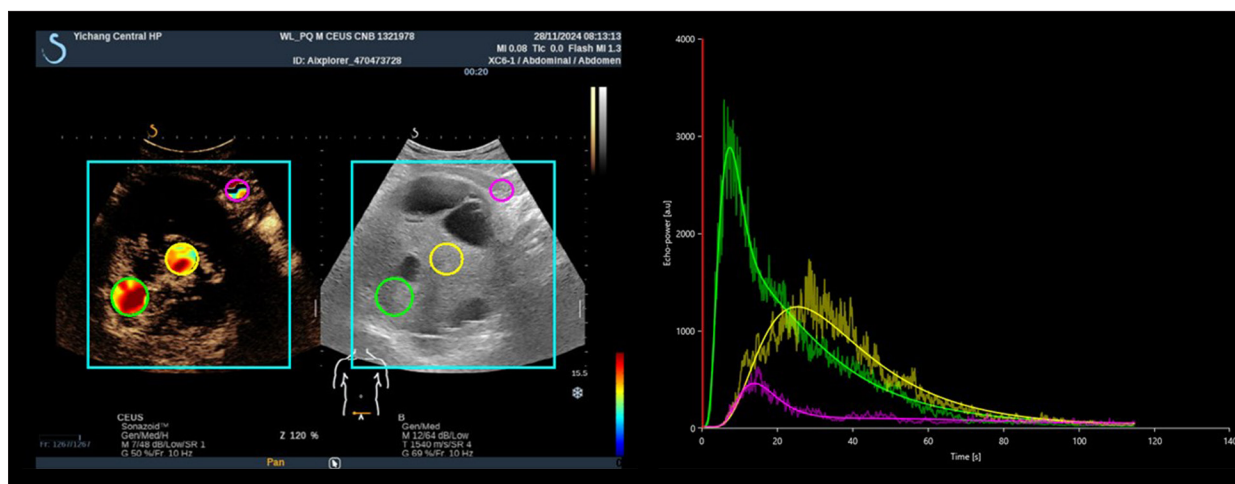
CEUSTIC analysis of pelvic schwannoma. RO1: peripheral tumor region (green); RO2: central tumor region (yellow); RO3: adjacent normal tissue (pink). The time to initial enhancement for RO1/RO2 was 10.68 s and 12.55 s, respectively, with a difference of no more than 2.3 s compared with RO3 (12.86 s), demonstrating an “equal-in” pattern. Late-phase enhancement showed WoAUC [au] values of 2.42×10^4 and 2.96×10^4 for RO1/RO2, versus 4.10×10^3 for RO3, consistent with a “slow-out” pattern. RO1 reached its peak earlier (TTP: 7.48 s vs 25.41 s) and exhibited higher peak intensity (PE: 2.87×10^3 au vs 1.23×10^3 au). CEUS, contrast-enhanced ultrasound; TIC, time-intensity curve; ROI, region of interest; WoAUC, washout area under the curve; TTP, time to peak.
